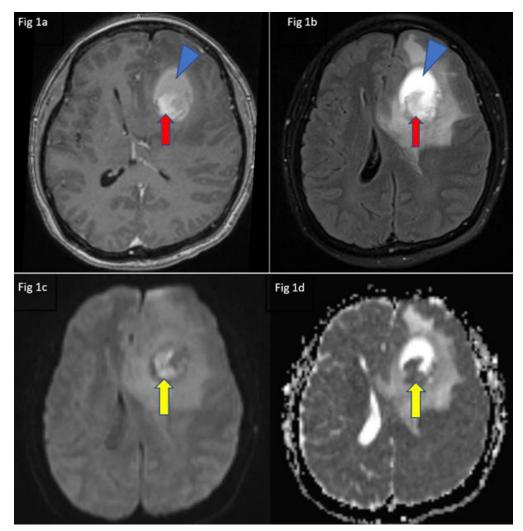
Axial plane magnetic resonance images: (a) contrasted T1, (b) FLAIR, (c) DWI and (d) ADC map. Figure 1a and b show a left frontal lobe mass with associated white matter oedema. The mass has a solid enhancing component located peripherally (red block arrow), which demonstrates restricted diffusion (yellow block arrow in Figure 1c and d). A large portion of the mass shows high signal intensity in the T1, T2 and FLAIR images, suggestive of necrotic components (blue arrowhead in Figure 1a and b). These findings favour a glioblastoma.
